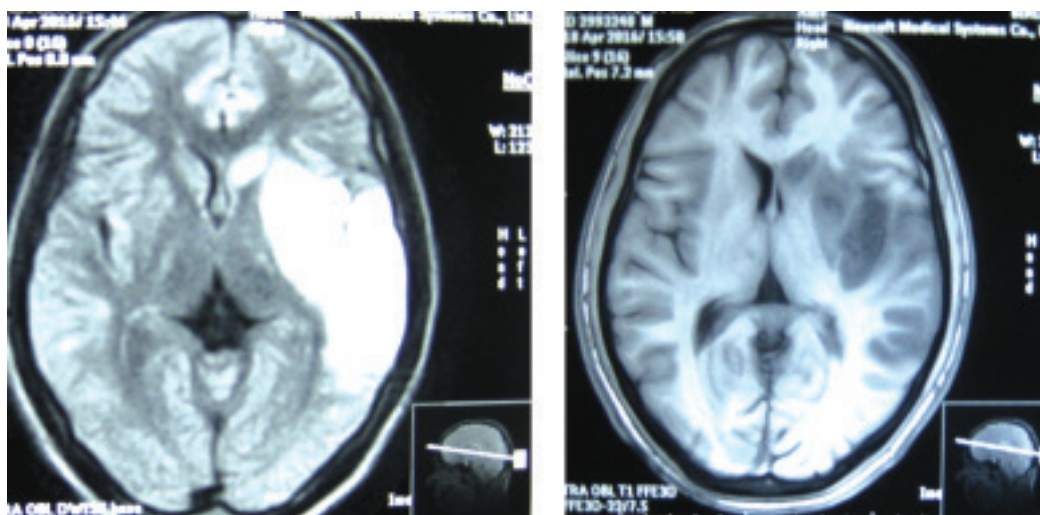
MRI of Brain showing acute large left MCA territory infarction with midline shifting and effacement of the left lateral ventricles.
